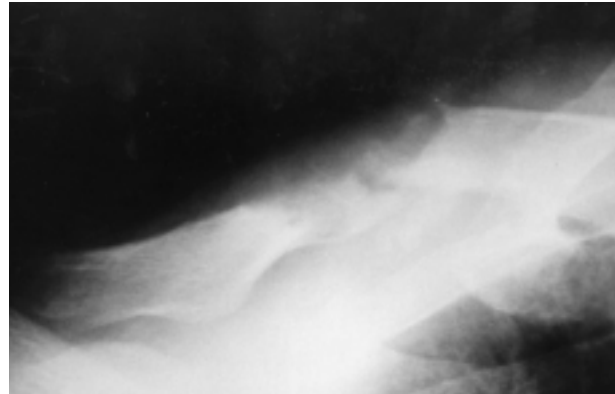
Patient 2*: Radiograph showing a pathological fracture in an osteolytic lesion in the middle third of the clavicle.
